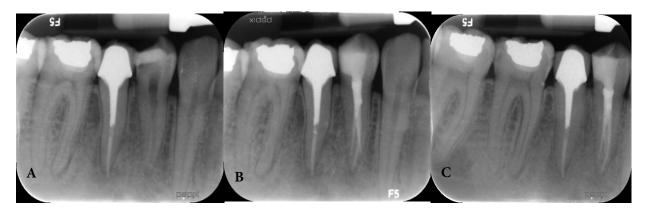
A) Preoperative periapical radiograph; B) Postoperative periapical radiograph; C) Three-month follow up radiograph
